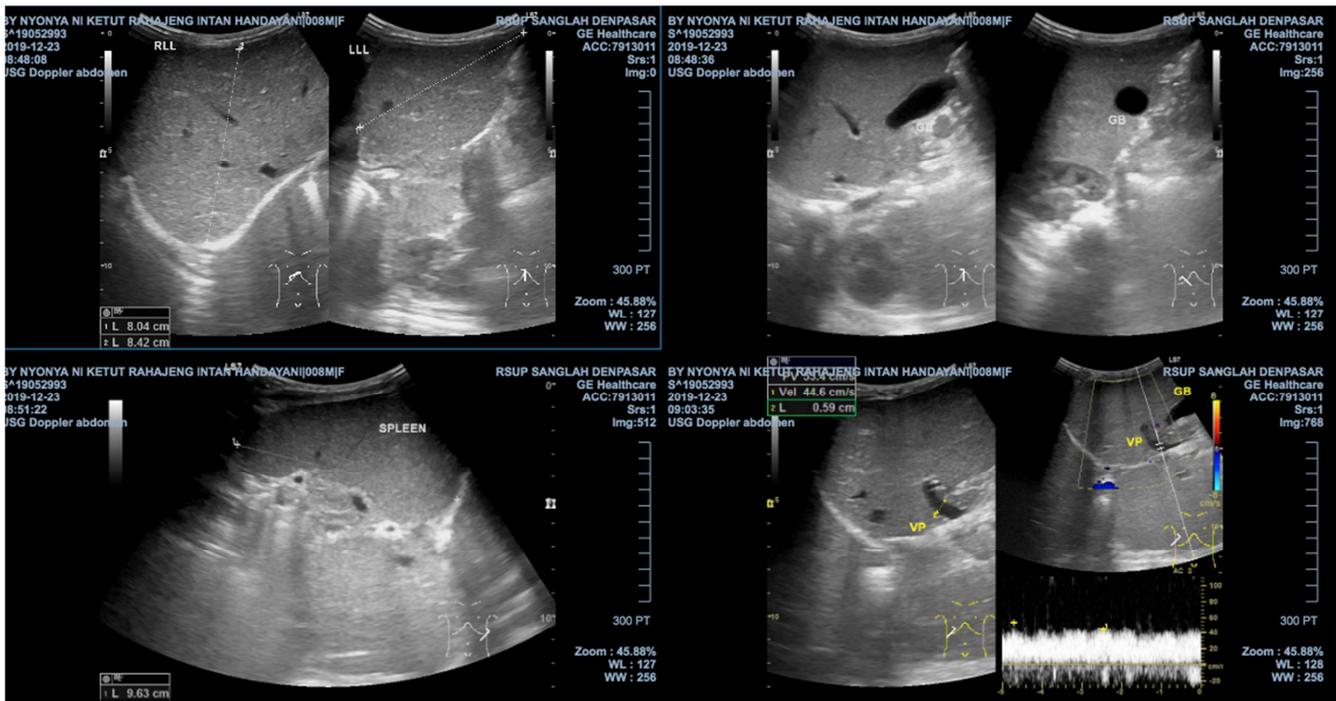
Abdominal Ultrasound.
